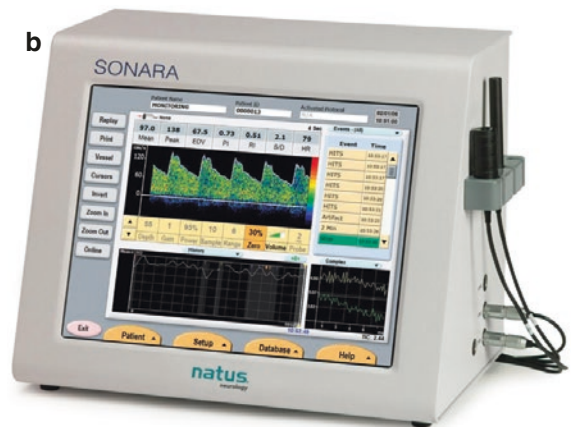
The SONARA Transcranial Doppler (TCD) systems; (a): complete system; (b) the monitor; (c) the monitor panel of SONARA demonstrating Doppler waves on different arteries; (d) SONARA/TEK Digital TCD
